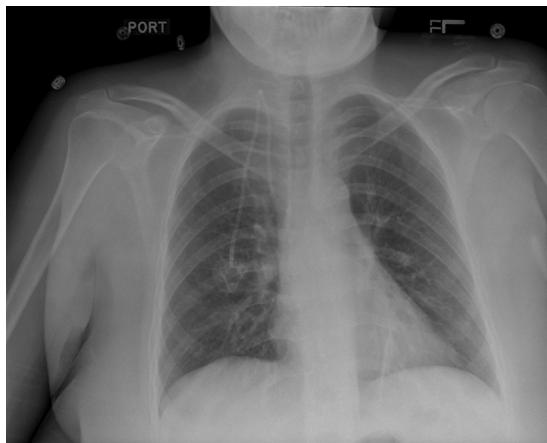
Portable anteroposterior chest radiograph demonstrating the placement of a double Port-a-Cath. (From North-central Technical College, Wausau, Wisconsin.)
